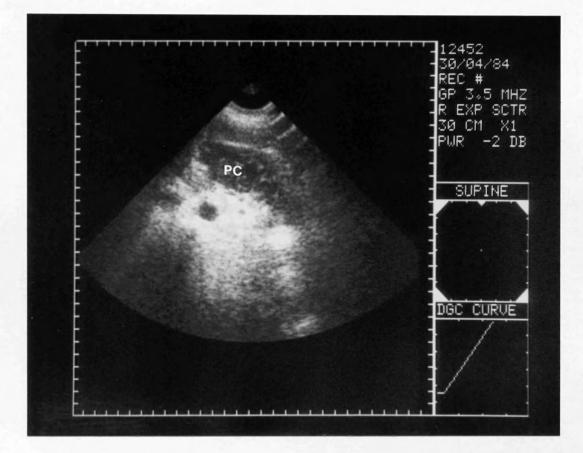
Ultrasound scan of a pseudocyst (same patient as Figure 24) following percutaneous aspiration. (dimensions not marked but echolucent area is obviously smaller than in figure 24).)
